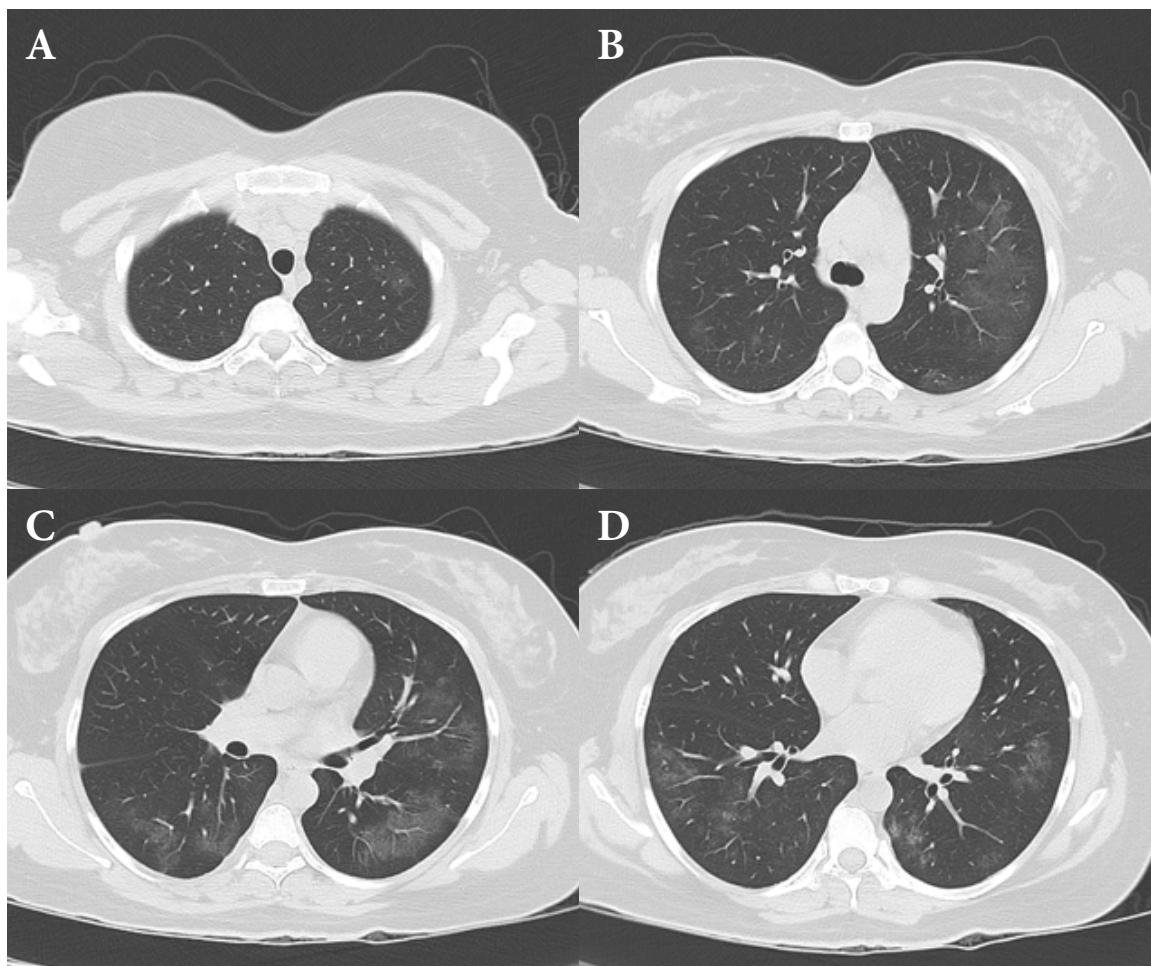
Axial non-contrast chest CT (A-D) shows resolutions of crazy-paving pattern with residual GGO at both lungs.
